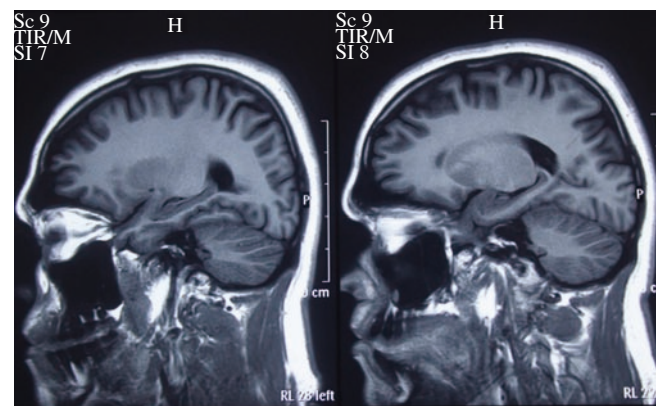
MRI sagittal view showing no cerebral & cerebellar changes with non-dilated ventricular system.
